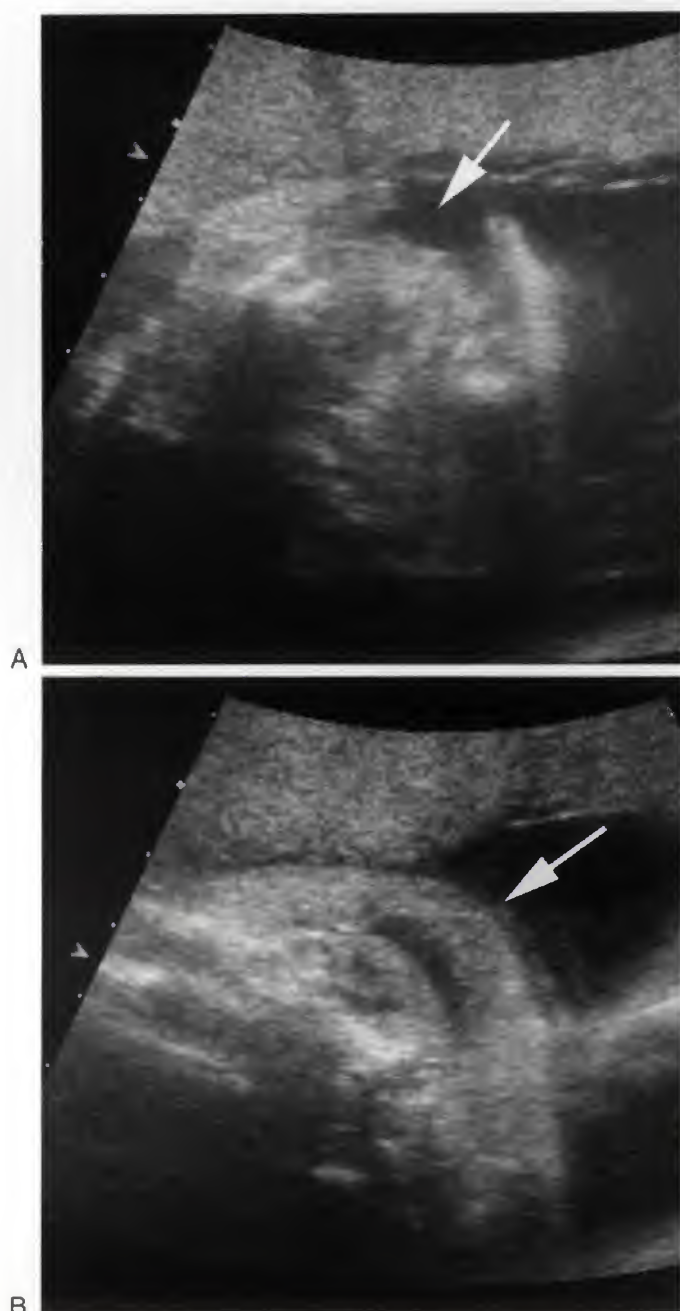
A.* Sonogram of a third trimester fetus demonstrates what appears to be scalp thickening (*arrow*). *B.* In a slightly wider field of view, it can be clearly seen that what appeared to be fetal scalp was in fact the wall of the maternal urinary bladder. Bl, bladder.
